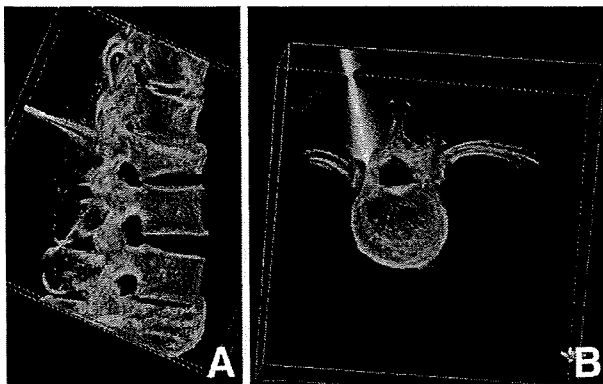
Three-dimensional radiographs with the tip of a 13-gauge needle inserted into the cortex at the lateral mass of the lamina. A: Lateral view, B: axial view.
